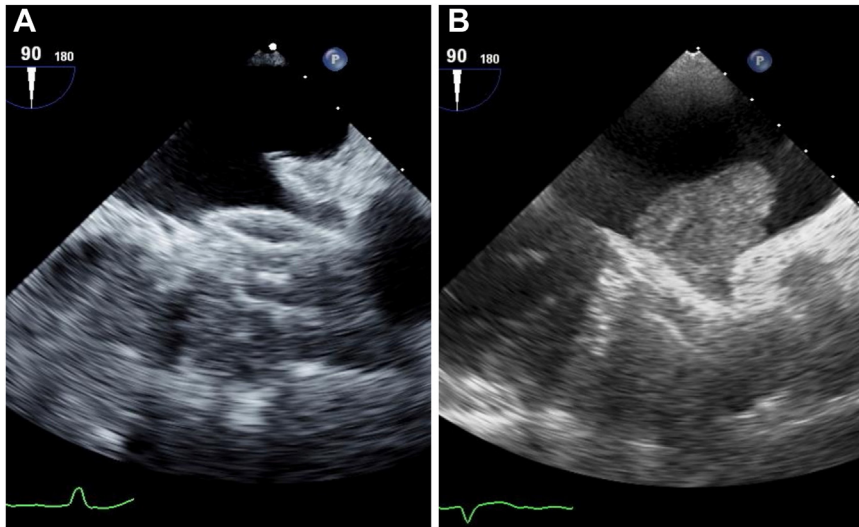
Transesophageal echocardiography image at 90°: A: immediately post Amulet device implant and B: at 6 months follow-up.
